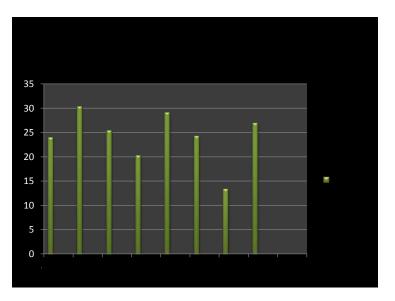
Retrospective phase departmental reject rate for extremity radiography for venue A
